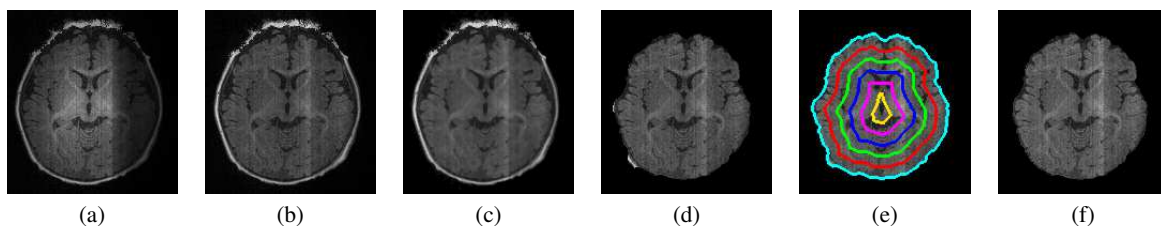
Step-wise brain extraction using the proposed framework: (a) the original MR image, (b) the bias-corrected image, (c) the GGMRF-smoothed image obtained with $\rho = 1$, $\lambda = 5$, $\beta = 1.01$, $\alpha = 2$, and $\eta_{s,r} = \sqrt{2}$, (d) the extracted brain using BET [2], (e) the iso-surfaces used to remove non-brain tissues, and (f) the final extracted brain.
